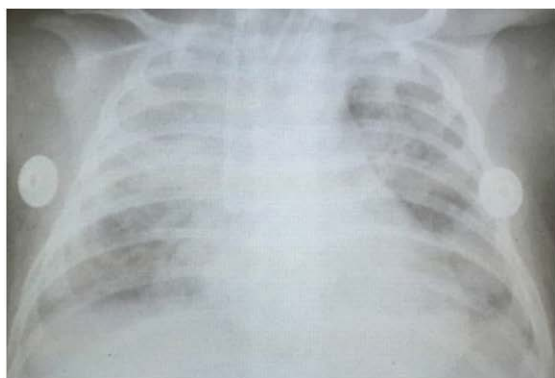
Chest X-ray on admission to PICU in Case 1.
